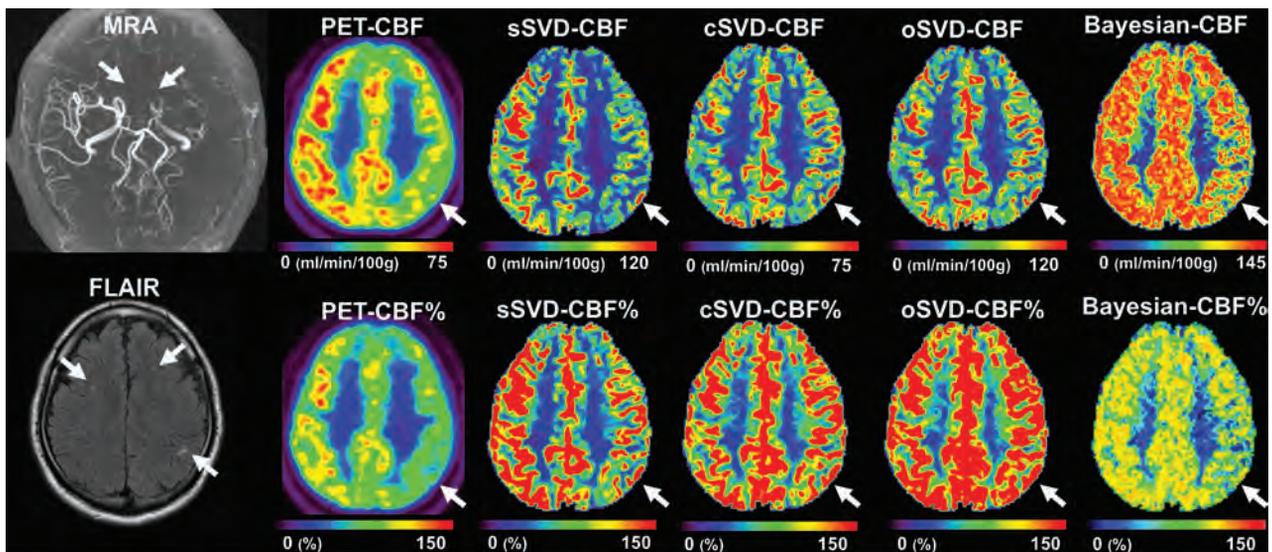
A representative case. A 48-year-old man was incidentally diagnosed with Moyamoya disease by nonspecific symptoms. MRA reveals occlusion of the terminal portion of the left ICA (arrows), bilateral anterior cerebral arteries, and the left MCA. FLAIR shows bilateral white matter hyperintensities. CBF maps obtained by PET, sSVD and Bayesian analysis shows clearly reduced CBF on the left sides (arrows). However, the CBF maps obtained by cSVD and oSVD do not show the laterality of the CBF that is evident on PET (arrows). The CBF% map of Bayesian analysis shows values close to the CBF% of PET. Please note that the color scale used in the raw CBF maps was the same as that used during the visual assessments and that the color scales of the CBF% maps were unified.
